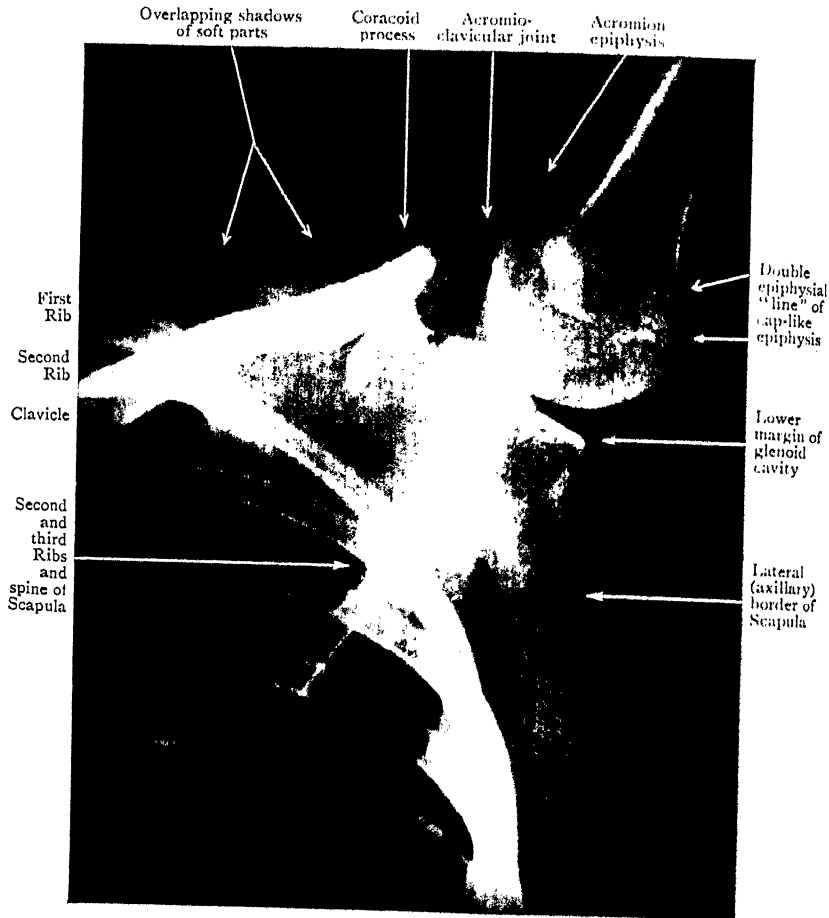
Radiograph of same Shoulder as in Fig. 38—arm fully abducted and raised above the head. Note that the movement of the Humerus has continued until the shaft is in line with the spine of the Scapula; note the further movement of the Scapula itself.
